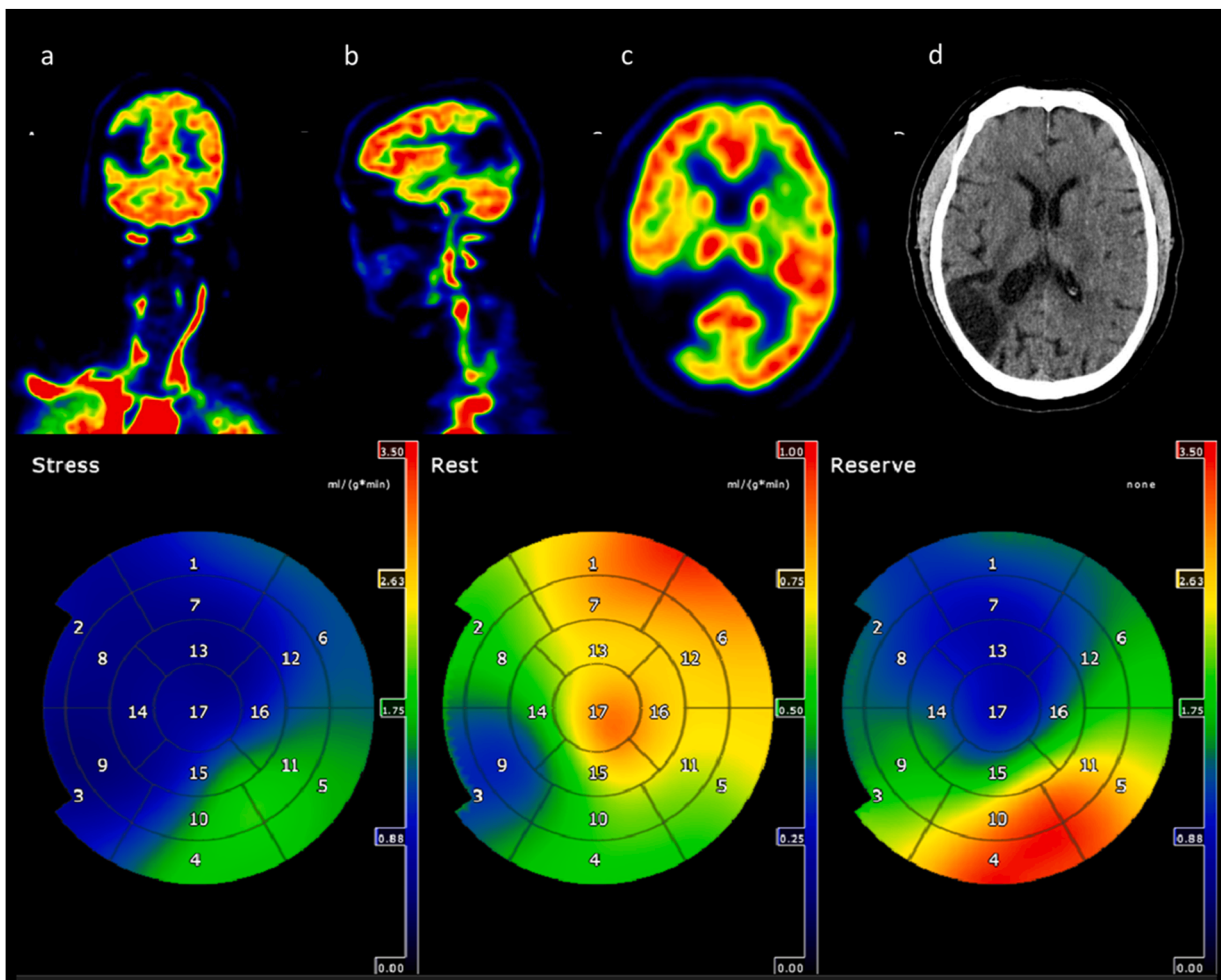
Brain infarction and myocardial ischemia detected by whole-body perfusion PET imaging using ^{15}O -water. Whole-body perfusion PET reveals a brain infarction in the parieto-occipital area in a patient undergoing myocardial perfusion imaging due to suspected CAD. Coronal (A), sagittal (B), and transaxial (C) PET slices from dynamic summed images, and corresponding CT image confirming cerebral infarction (D). The patient had recovered from stroke and was referred to myocardial perfusion imaging due to angina. Polar maps show reduced stress myocardial blood flow (MBF, lower left panel) throughout the left ventricular myocardium, whereas rest MBF (lower middle panel) is reduced in the inferior part of the interventricular septum. Myocardial flow reserve (MFR, lower right panel) is severely reduced in the left anterior descending coronary artery territory. Coronary angiography showed chronic total occlusion of the LAD, diffuse CAD in the right coronary artery, and intermediate stenosis in the left circumflex coronary artery. This example demonstrates the feasibility of whole-body perfusion imaging in detecting clinically relevant extra-cardiac findings in combination with myocardial perfusion imaging. CAD, coronary artery disease; CT, computed tomography; PET, positron emission tomography.
